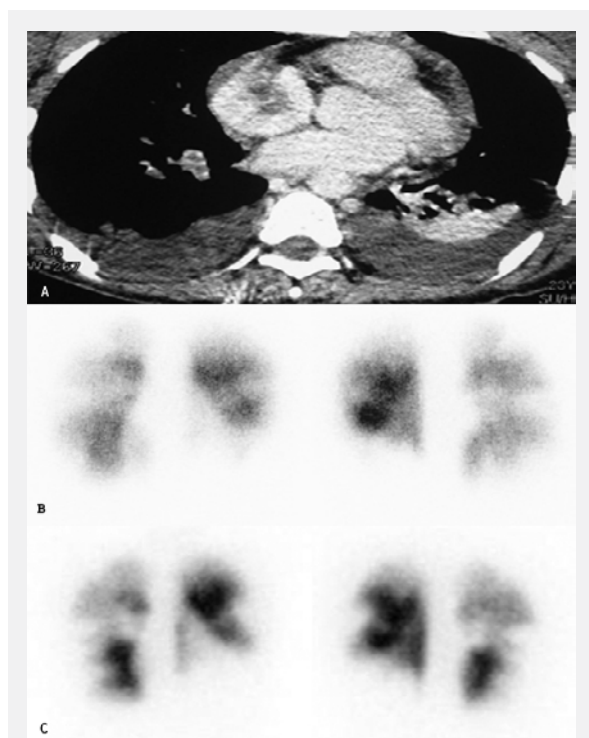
On CT angiography of the 19 year-old female patient who presented with vena cava superior syndrome with severe dyspnea showed thrombotic occlusion of jugular veins, subclavian veins, vena cava superior, pulmonary arteries as well as right atrium (A). The patient went well without any symptom after 13 years of presentation with intense immunosuppressive treatment and anticoagulation lasting almost 5 years. Anterior and posterior perfusion lung scintigraphy images (B) of patient showed segmental and subsegmental perfusion defects in left and right lungs. After about 13 years of follow-up, newly formed and narrowed defects in the right and left lungs were determined (C). This patient is an example of “thrombotic pulmonary disease” (Gr-1b).
